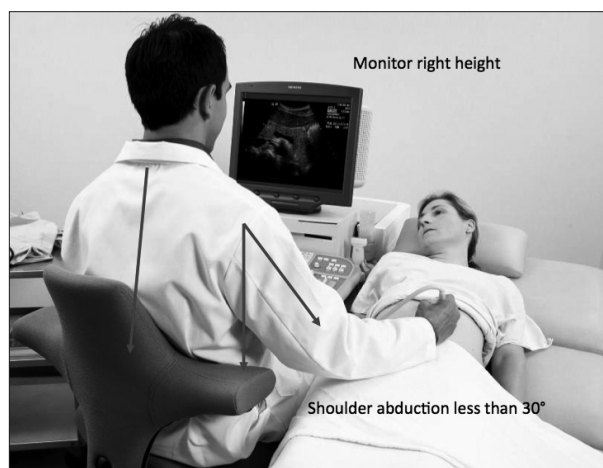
A and B, Good postural alignment and equipment positioning. The monitor is the correct height in both images; the chair and table are also correct with the sonographer's elbow at 90°. The shoulder is less than 30° abducted. The sonographer's feet are supported on the ring of the chair. The chair back is supporting the sonographer. Both sonographers' shoulders are not abducted; their necks and trunks are not twisted. A, Reproduced with permission from Philips Healthcare. B, Reproduced with permission from Siemens Medical Solutions (Mountain View, CA).
